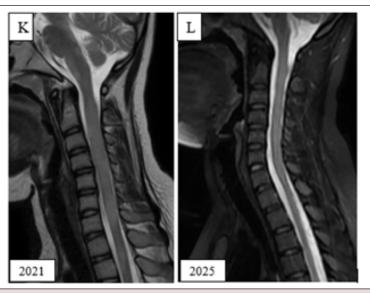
MRI spine: Interval resolution of transverse myelitis (2021 vs 2025) (Case 1).
